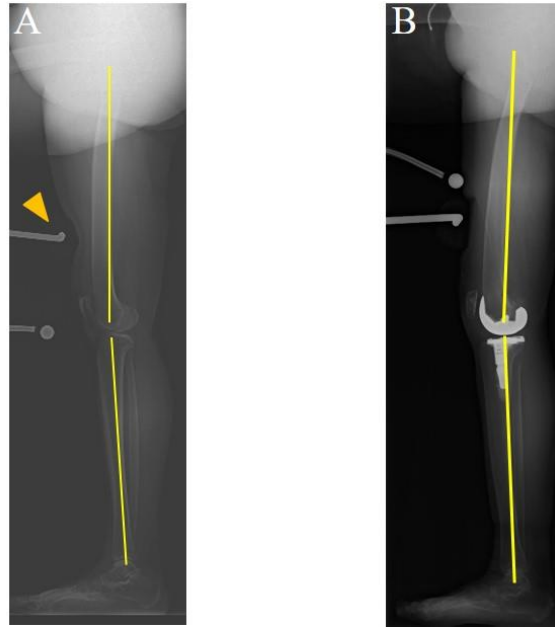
Stress radiographs showing pre- and post-operative knee extension angles. (A) Measurement of the pre-operative knee extension angle as the mechanical axis of the femur and lower leg using lateral stress radiographs, including the femoral head, knee, and ankle. An extension force of 15 N was applied to the front of the distal femur (arrowhead) to maximize the knee extension. (B) Post-operative knee extension angle. The knee extension angle was evaluated as a pre-operative procedure.
